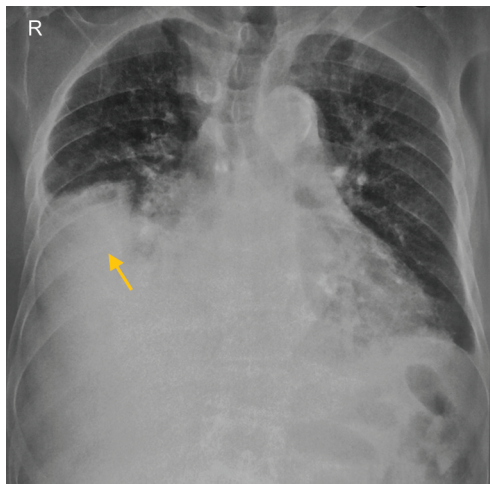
Chest radiograph showing right-sided pleural effusion in posteroanterior view. The arrow points to the effusion present in the right middle and lower zones
